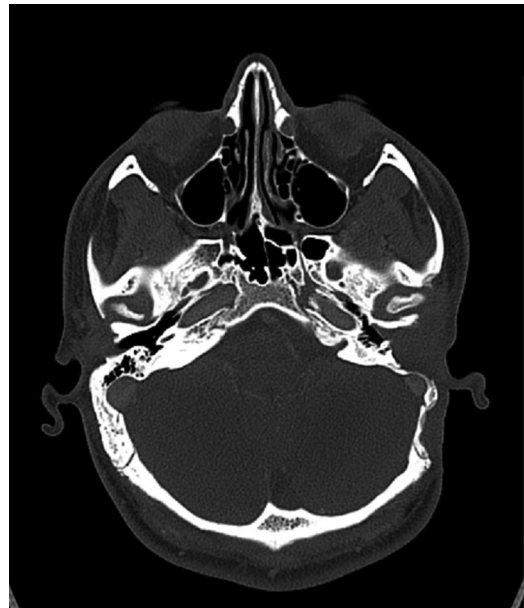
Follow-up temporal bone computed tomography scan obtained 3 months postoperatively, showing no signs of disease recurrence.
